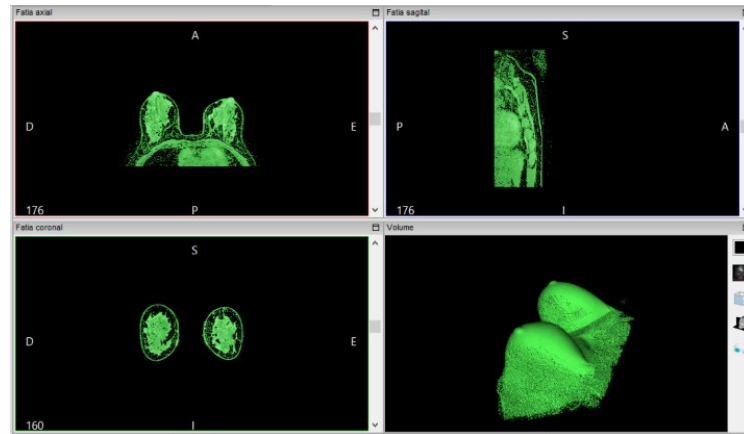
3D breast reconstruction using Magnetic Resonance Image
